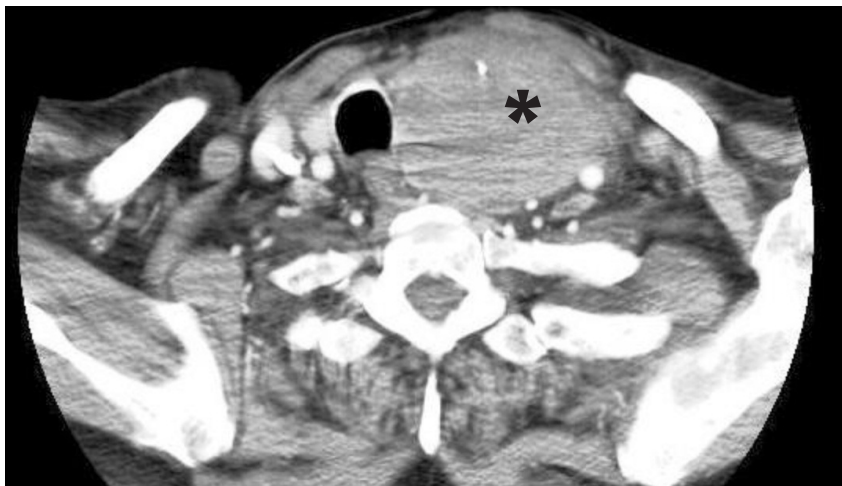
CT scan of the neck showing left thyroid lobule hematoma (asterisk).
